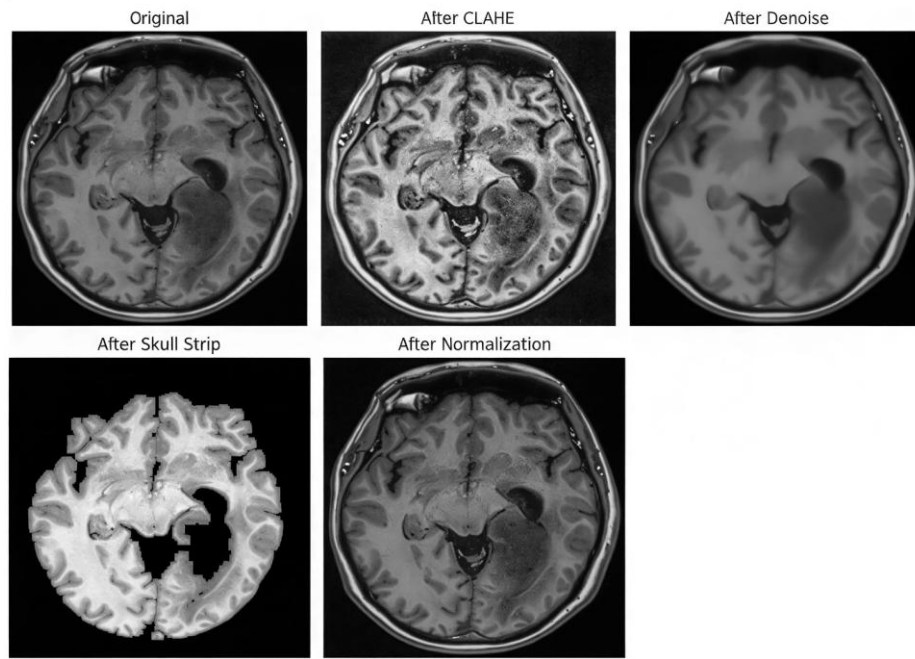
Visual comparison of preprocessing techniques applied to the same glioblastoma MRI image.
